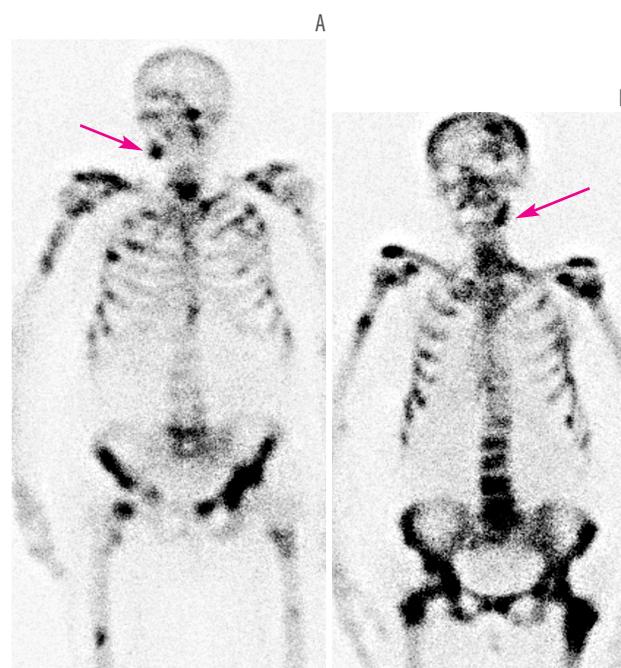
¹⁵³Sm-EDTMP scintigraphy scans showing focal hot spots in the right mandible in a patient with breast cancer (A) and in the left, mandible in a patient with prostate cancer (B) (arrows).
